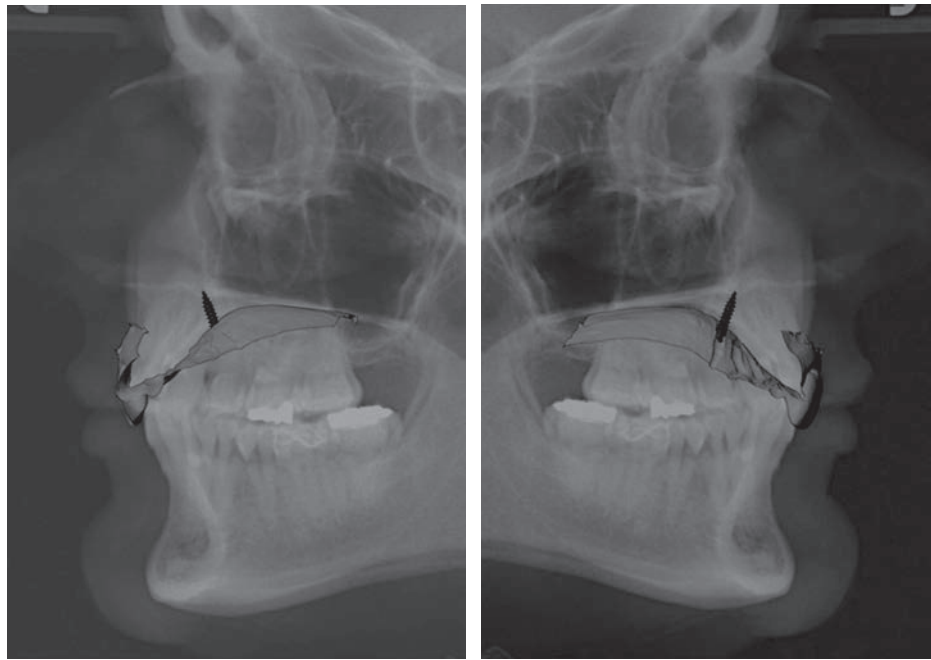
Virtual Mini-implant Placement. The stereolithographic file of the upper jaw is merged with a lateral cephalometric radiograph.
